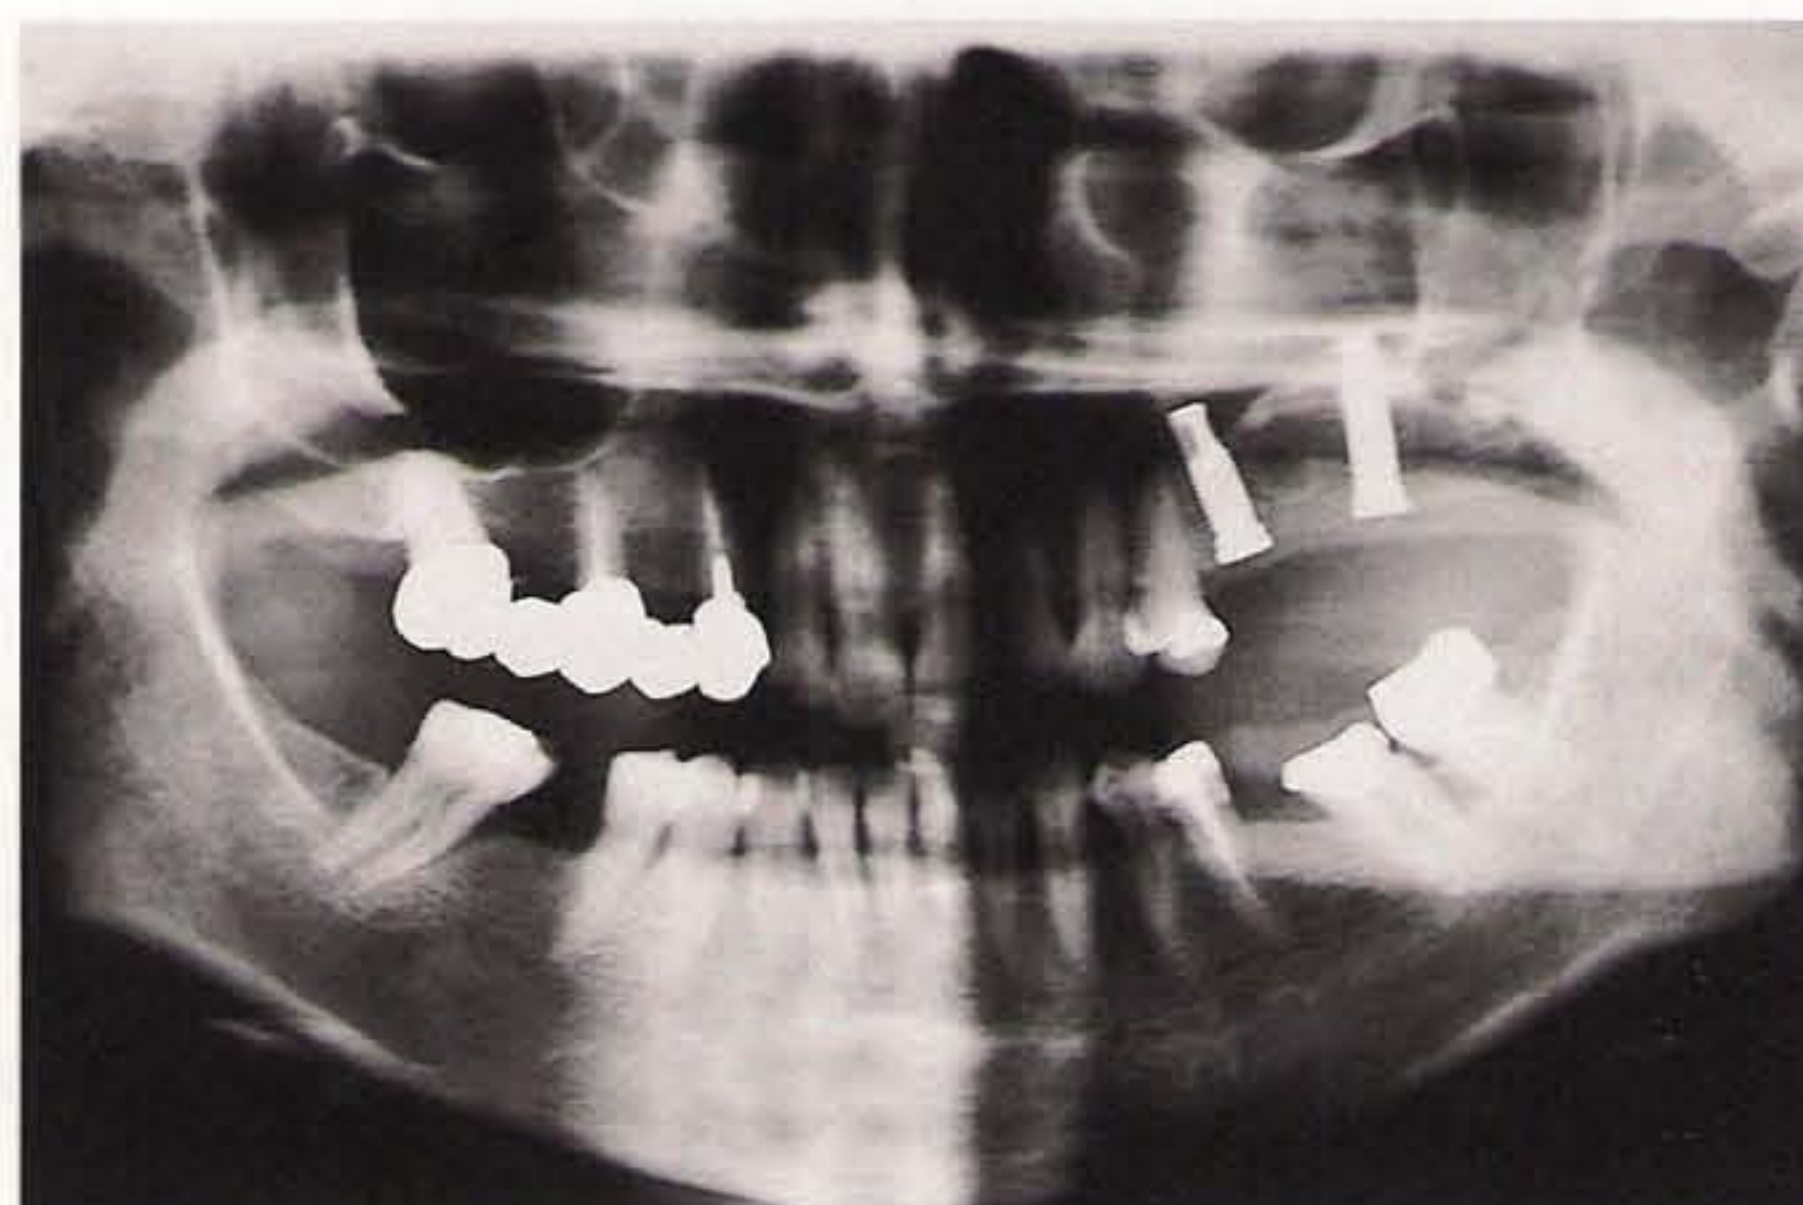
Panoramic radiograph made after placement of the implant.
